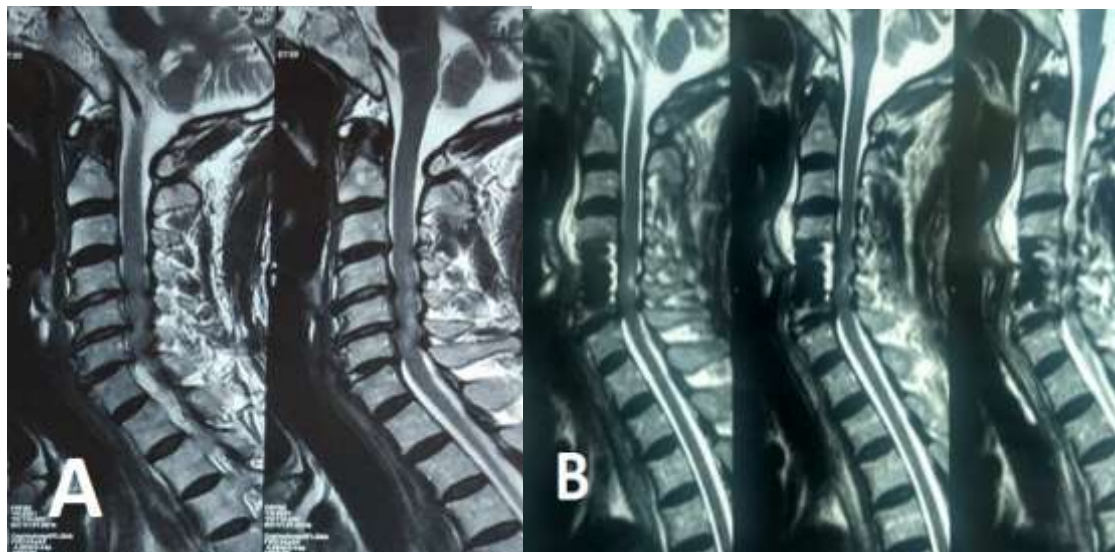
Pre-operative MRI (A) and Post-operative (B) MRI images of another 55 years old patient with compressive cervical myelopathy who underwent C5-6 corpectomy with standalone cage fusion.
